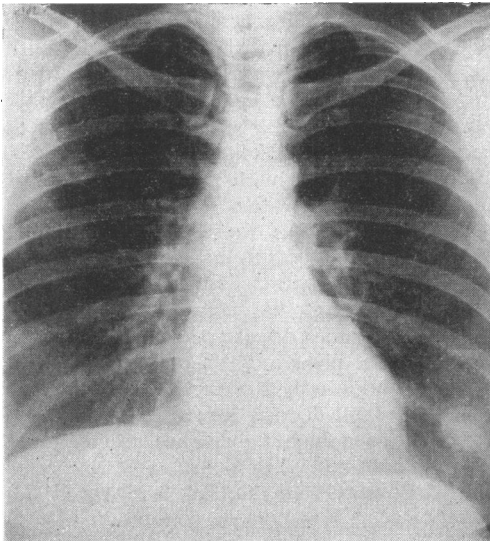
Case 1 Radiograph of chest, September 1960, showing enlargement of some of the round shadows
